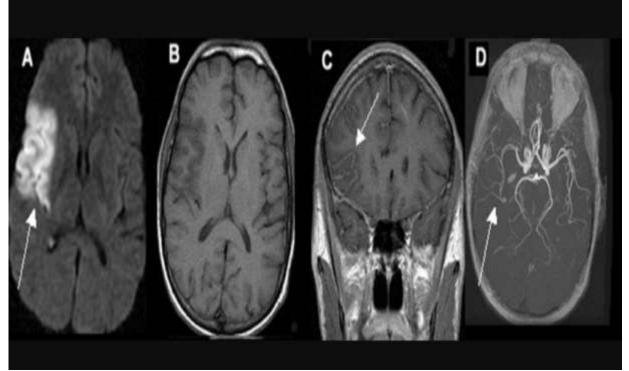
MRI chronic infarction
